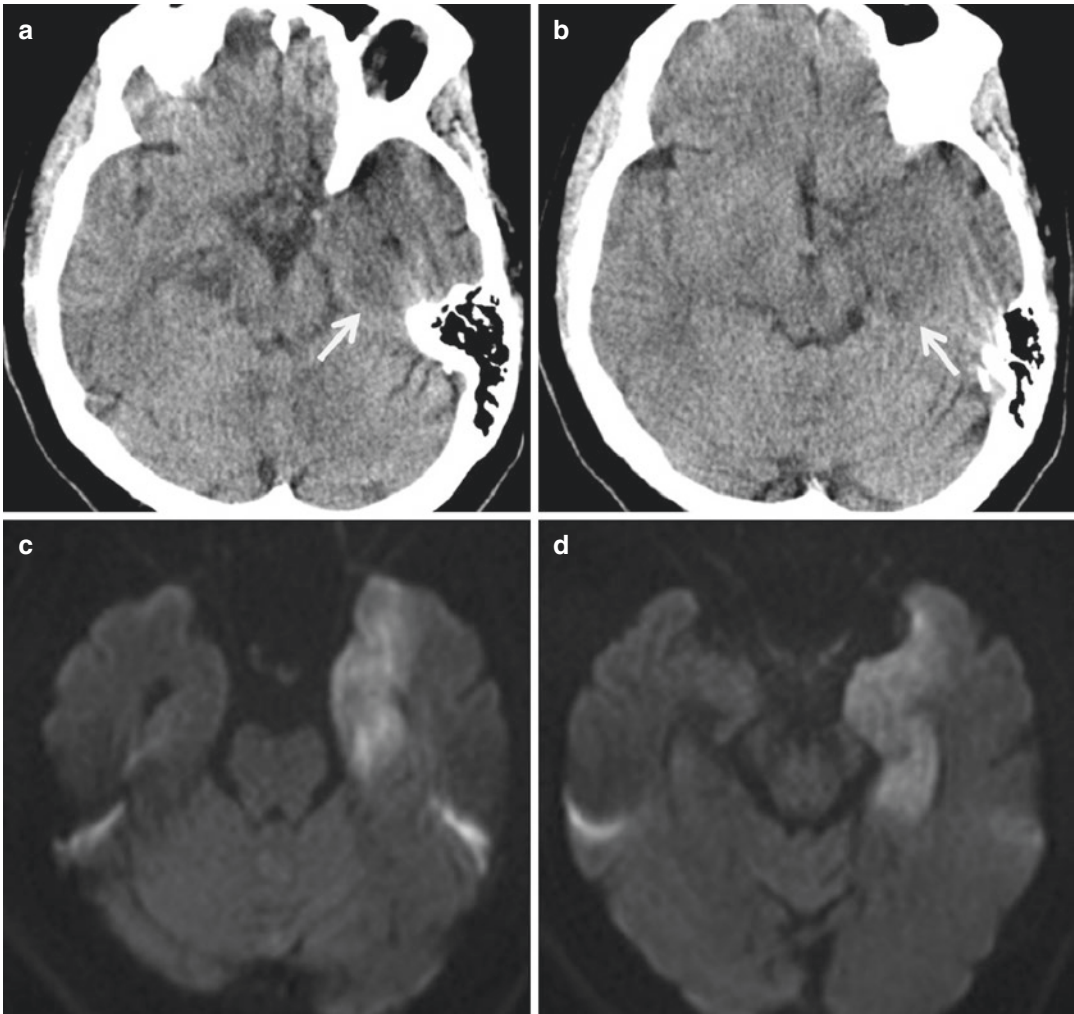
Herpes encephalitis. (a and b) CT sections: presence of an ill-defined low-attenuation area in the left medial temporal lobe. (c and d) DWI axial sections: The
